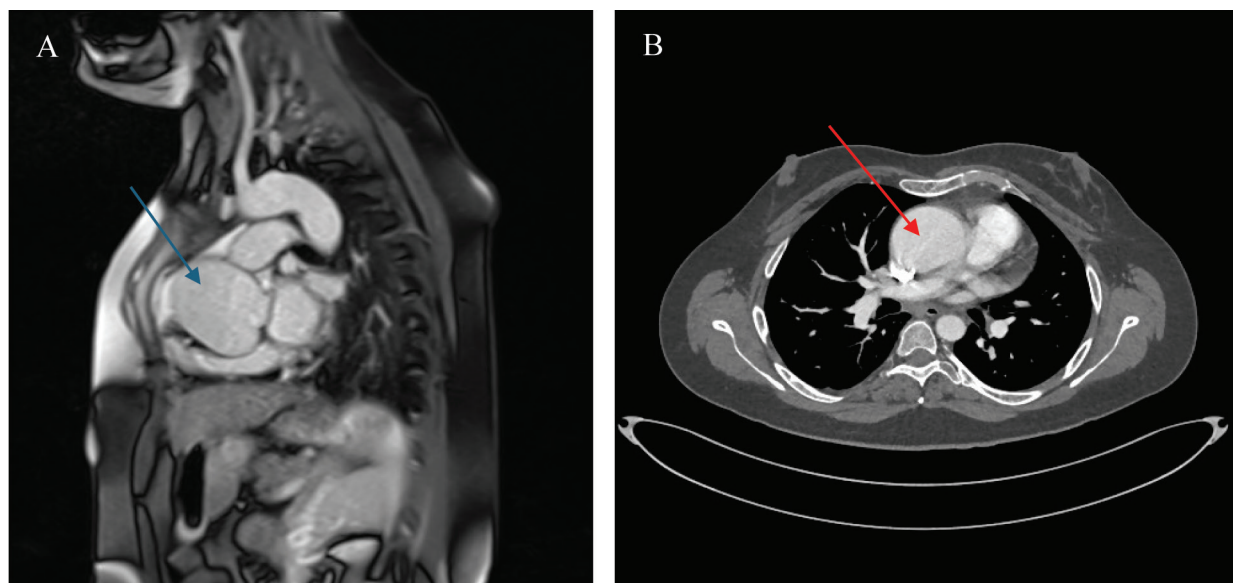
A) MR image of the dilated aortic root (blue arrow); B) dilated ascending aorta on CT scan (red arrow).
